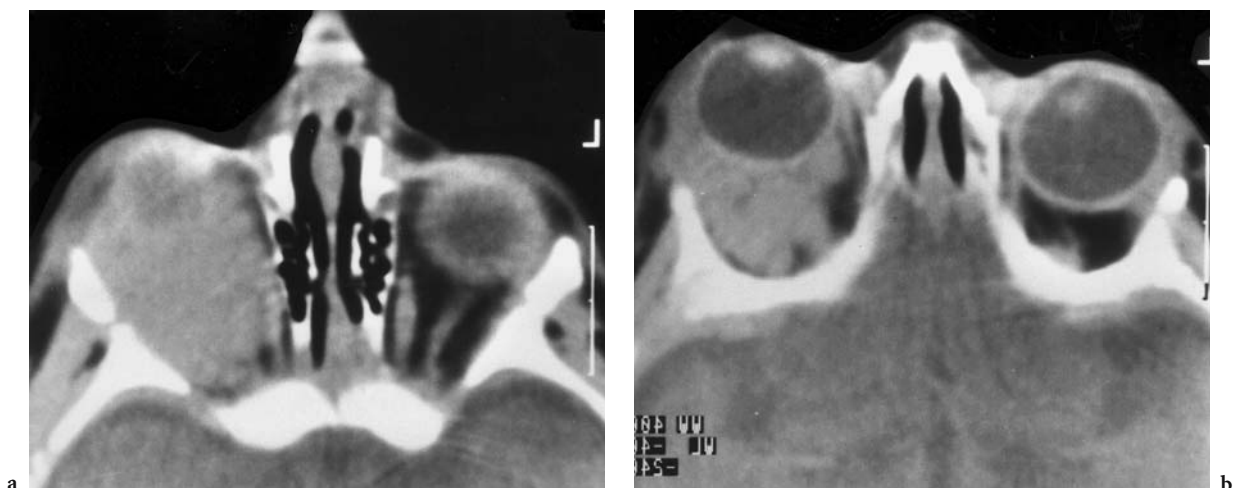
A 3-month-old boy with progressive exophthalmos developing in the 2nd and 3rd month of life; accentuated when screaming. Diagnosis: juvenile hemangioma. Axial CT: a Homogeneous, irregular mass is seen throughout the entire enlarged right orbit; no differentiation of normal orbital structures except in the apex region, where a well-demarcated small medial rectus muscle can be identified. b Showing the apparent protrusion of the globe
